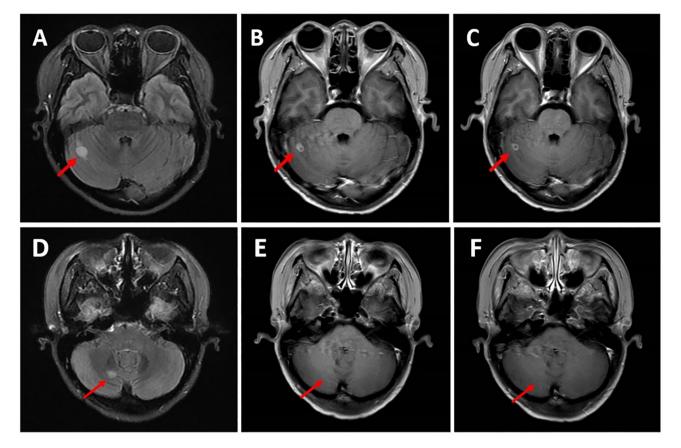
Brain MRI showing the patient response after treatment with utidelone combined with anlotinib. MRI scans (A,D) at baseline, (B,E) after two cycles of treatment and (C,F) after four cycles of treatment. Metastatic size reduction was as follows: (A) 11.5 mm, (B) 6.2 mm and (C) 4.5 mm; (D) 10.0 mm, (E) 0 mm and (F) 0 mm. The red arrows indicate the metastases. MRI, magnetic resonance imaging.
